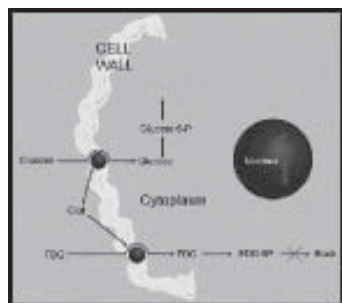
FDG uptake mechanism
